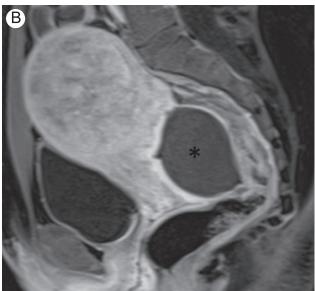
A 31-year-old woman presenting with acute pelvic pain secondary to an infarcted fibroid. Sagittal T2-weighted (A) MR image shows intermediate to hyperintense fibroid (black asterisk) protruding into the rectouterine space, connected posteriorly to the lower uterus by a stalk (arrow). Large hypointense fibroid superiorly (white asterisk) should be noted. (B) Contrast-enhanced MR image shows absent enhancement of the posterior pedunculated fibroid (black asterisk) compatible with infarction in the context of acute torsion, found on laparoscopy.
